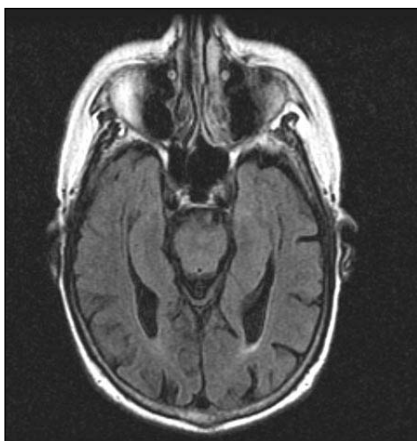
MR imaging in the day following ingestion shows restricted diffusion (DWI, figure 1) and associated T2-weight hyperintensity (FLAIR, figure 2) in the right occipital lobe as well as accompanying ischemic foci in the parietal lobes (DWI, figure 3)
